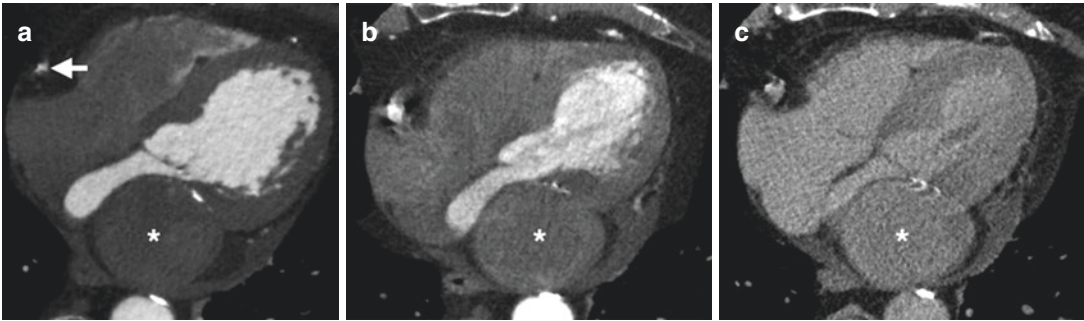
Cardiac CT in a Kawasaki patient with a giant circumflex artery aneurysm. (a) Coronary arterial phase—there is no enhancement of the circumflex artery aneurysm (asterisk) although note that contrast has already enhanced the right coronary artery (arrow). (b) Late arterial phase—uneven attenuation is present throughout the aneurysm
